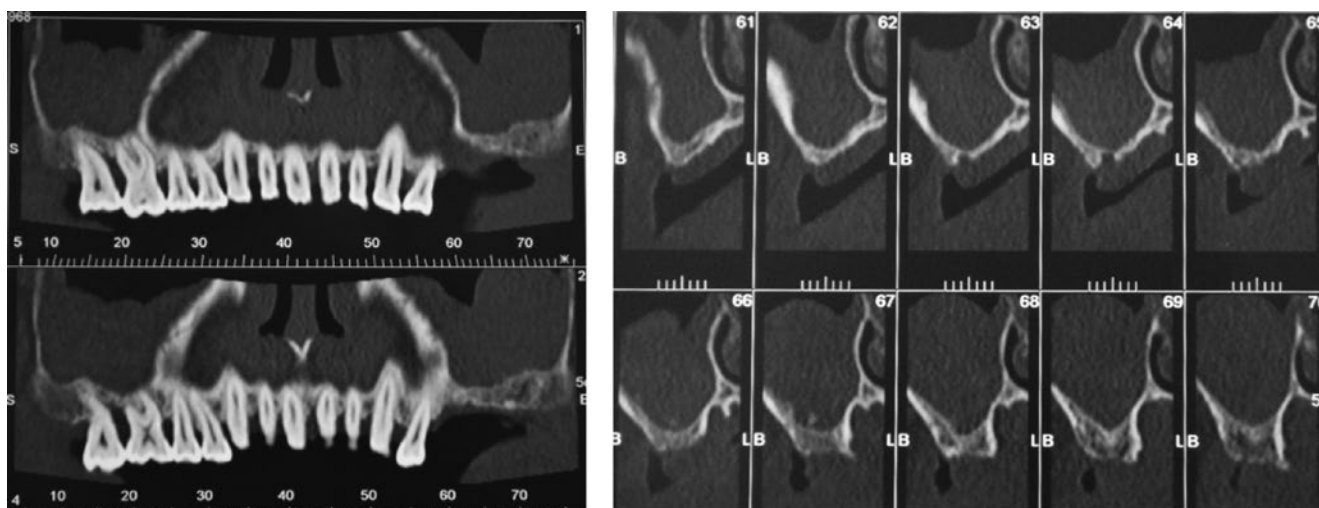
CT scan of patient D., right and left maxillary alveolar process atrophy and polyp of the maxillary sinus are visualised.
